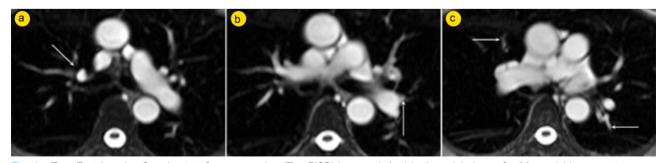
True Fast Imaging Steady-state free precession (TrueFISP) images (a,b,c) in the axial plane of a 30 year/old pregnant woman with suspected pulmonary embolism, showing different pulmonary vessel parts. Notice the good image quality, signal intensity and definition allowing for confident diagnosis of the main left pulmonary artery (a), emergence of the right superior lobar artery (arrow, a), the main right pulmonary artery (b) and segmental vessel parts including middle lobe and left lower lobe (arrows, c) pulmonary arteries. Notice the emergence of the left lower lobe segmental branches (arrow, b). No pulmonary embolism was found at chest MRI or suspected at clinical follow-up.
